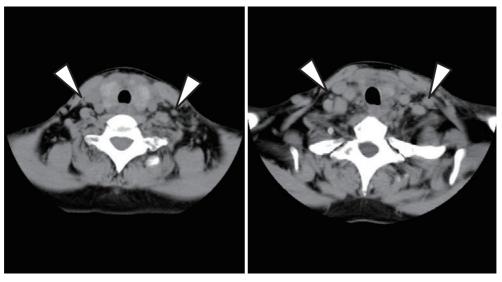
Computed tomography of the thyroid and lateral neck. Computed tomography scan of the thyroid and lateral neck revealed a heterogeneous thyroid gland and lateral lymph node swelling (white-headed arrows).
